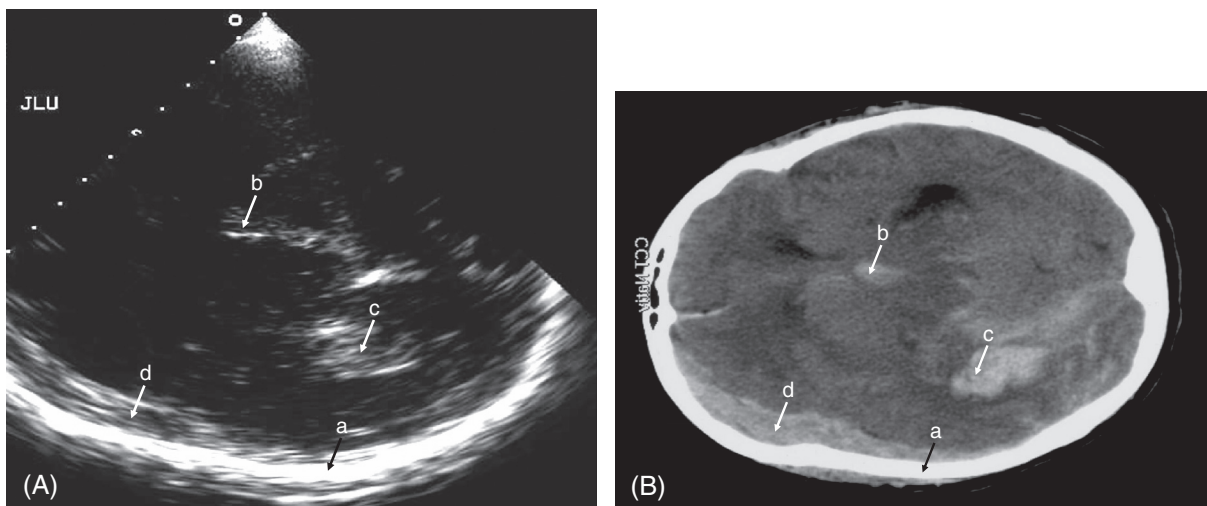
Transcranial sonography (A) and computed tomography (B) of a comatose patient. a = contralateral skull; b = third ventricle (tamponaded with blood); c = lateral ventricle (tamponaded with blood); d = subdural hematoma.
